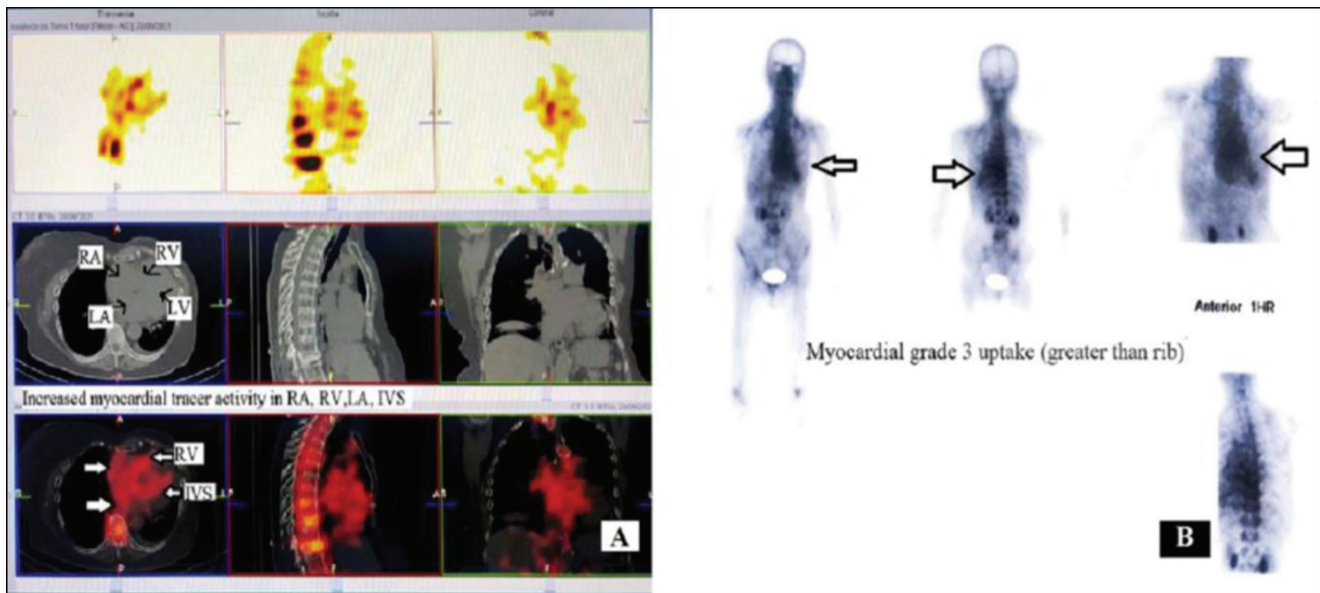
^{99m}Tc Pyrophosphate scintigraphy for cardiac amyloidosis (A) SPECT-CT showing increased myocardial tracer activity in the RA, LA, RV, and IVS (solid white arrows), (B) Semiquantitative visual grading of myocardial ^{99m}Tc PYP uptake in comparison to rib uptake—grade 3 (more than rib) (black arrows). Abbreviations: LV: left ventricle, LA: left atrium, RA: right atrium, RV: right ventricle, IVS: interventricular septum, SPECT-CT: single photon emission computed tomography
